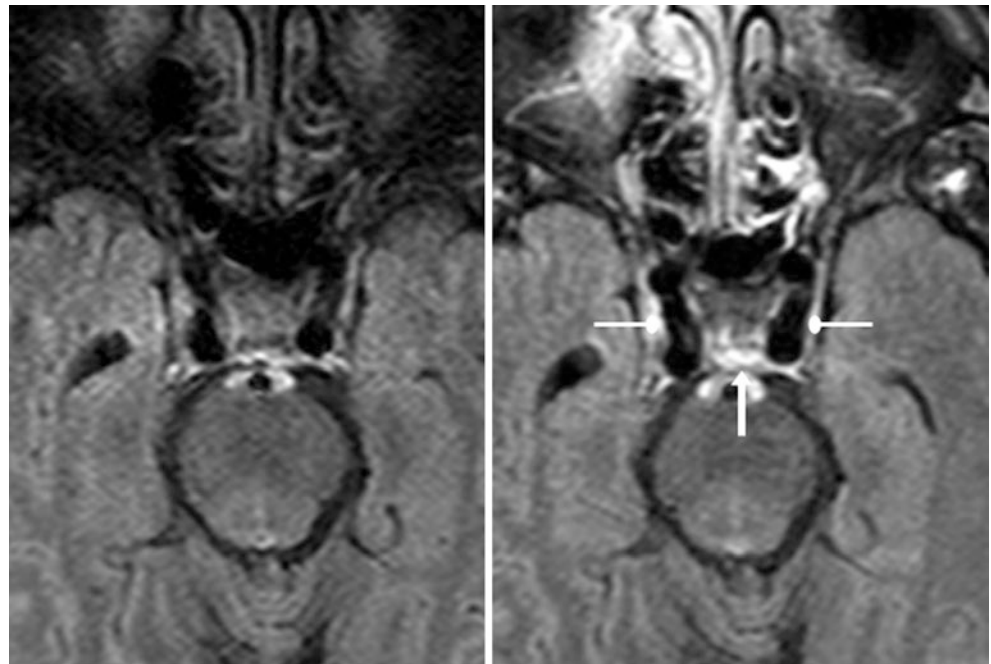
57-year-old with enhancement of the PIS (*arrows*) and cavernous sinus (*oval-tip arrows*), as demonstrated on axial precontrast (*left*) and postcontrast (*right*) FLAIR MRI. The AIS is not visualized
